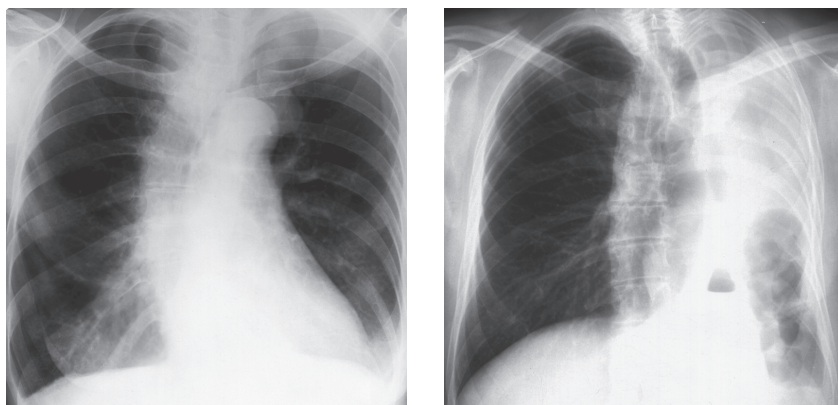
Frontal X-ray. Left-sided scoliosis of the thoracic spine
